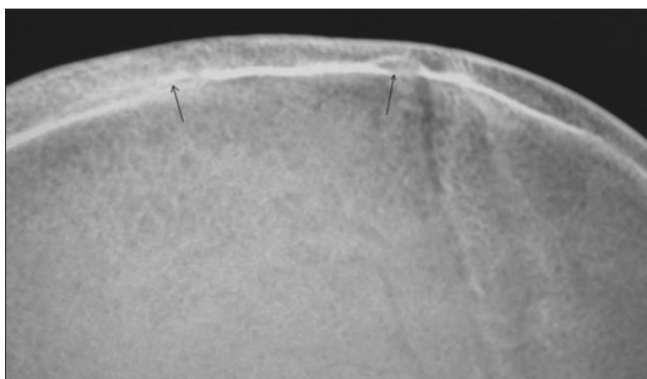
X-ray skull showing break in continuity of inner skull margin
